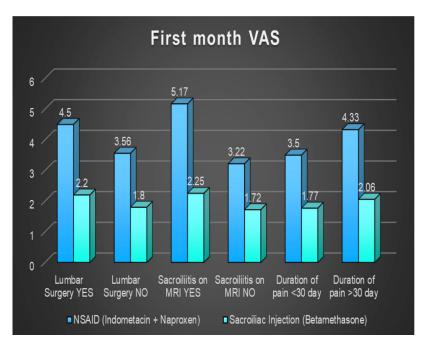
VAS scores at the first month after treatment are shown according to whether or not lumbar surgery was performed, whether there was sacroiliitis, and the duration of pain. VAS: Visual Analogue Scale, NSAID: Nonsteroidal anti-inflammatory drug, MRI: Magnetic resonance Imagining.
